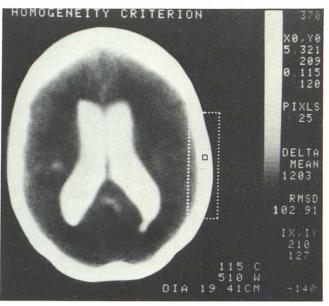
Homogeneity criterion applied to calvarial bone. Within user-defined rectangular region of interest, 25 pixel square with $500 < \bar{X} < 1500$ Delta units and smallest variance is outlined in black (root mean square 102.91, CT number 1203 Delta units).
